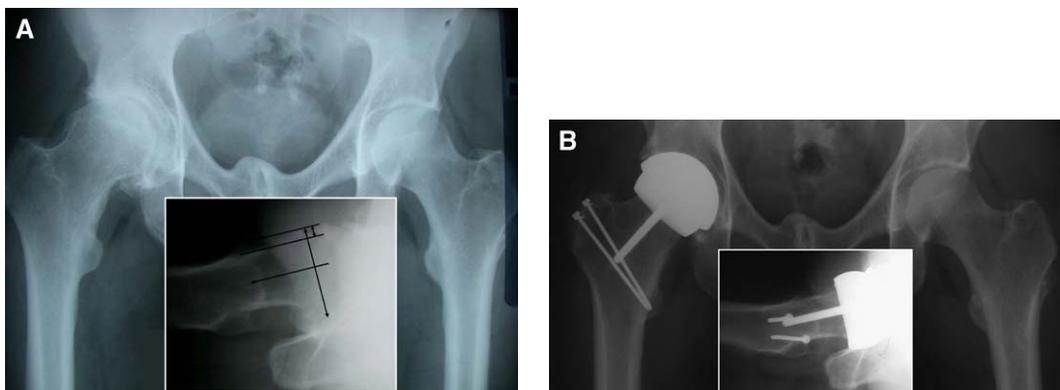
(A) Anteroposterior radiograph showing aspherical femoral head with advanced arthritic changes. Inset demonstrates offset ratio measurement on the cross-table lateral radiograph. (B) Postoperative anteroposterior radiograph at 2 years post metal-on-metal hip resurfacing. Inset shows appropriate offset restoration on the cross-table lateral radiograph.
